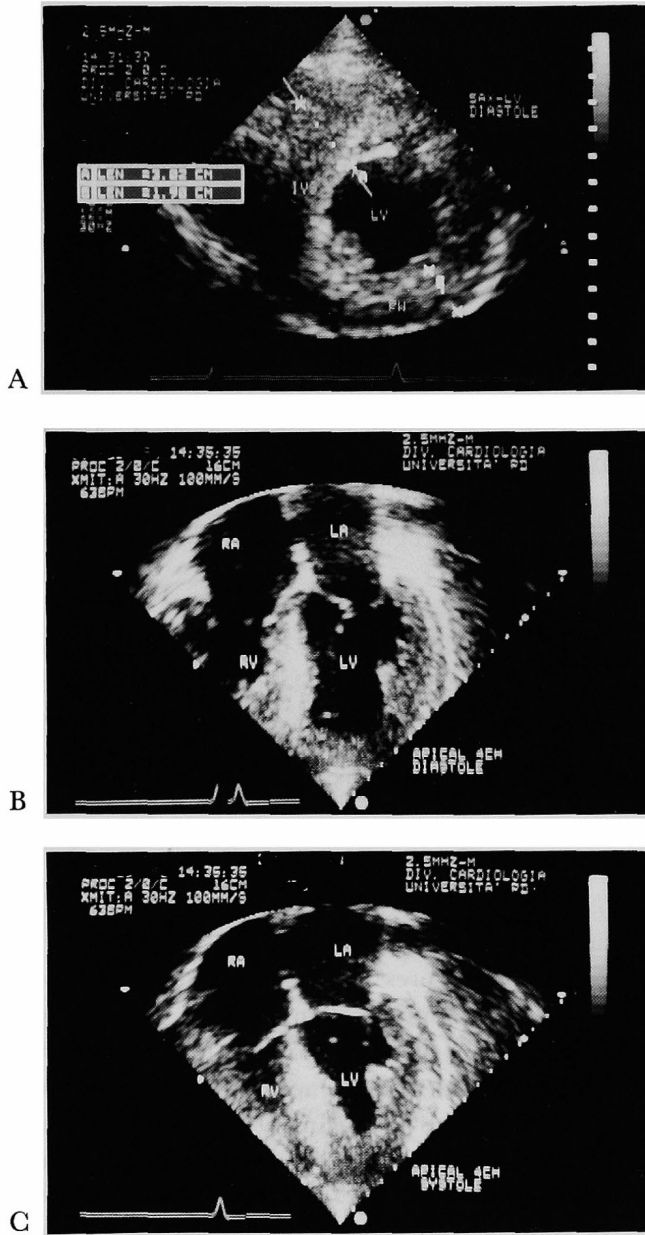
Stop frames of two-dimensional echocardiograms from patient 2 with hypertrophic cardiomyopathy. A: parasternal short-axis view at level of papillary muscles, showing severe hypertrophy of the ventricular septum. B, C: apical four-chamber views during diastole (B) and systole (C) showing hypertrophy confined to mesoventricular and apical portions of the ventricular septum and lateral wall. IVS=intraventricular septum; LA=left atrium; LV=left ventricle; PW=posterior wall; RA=right atrium; RV=right ventricle.
